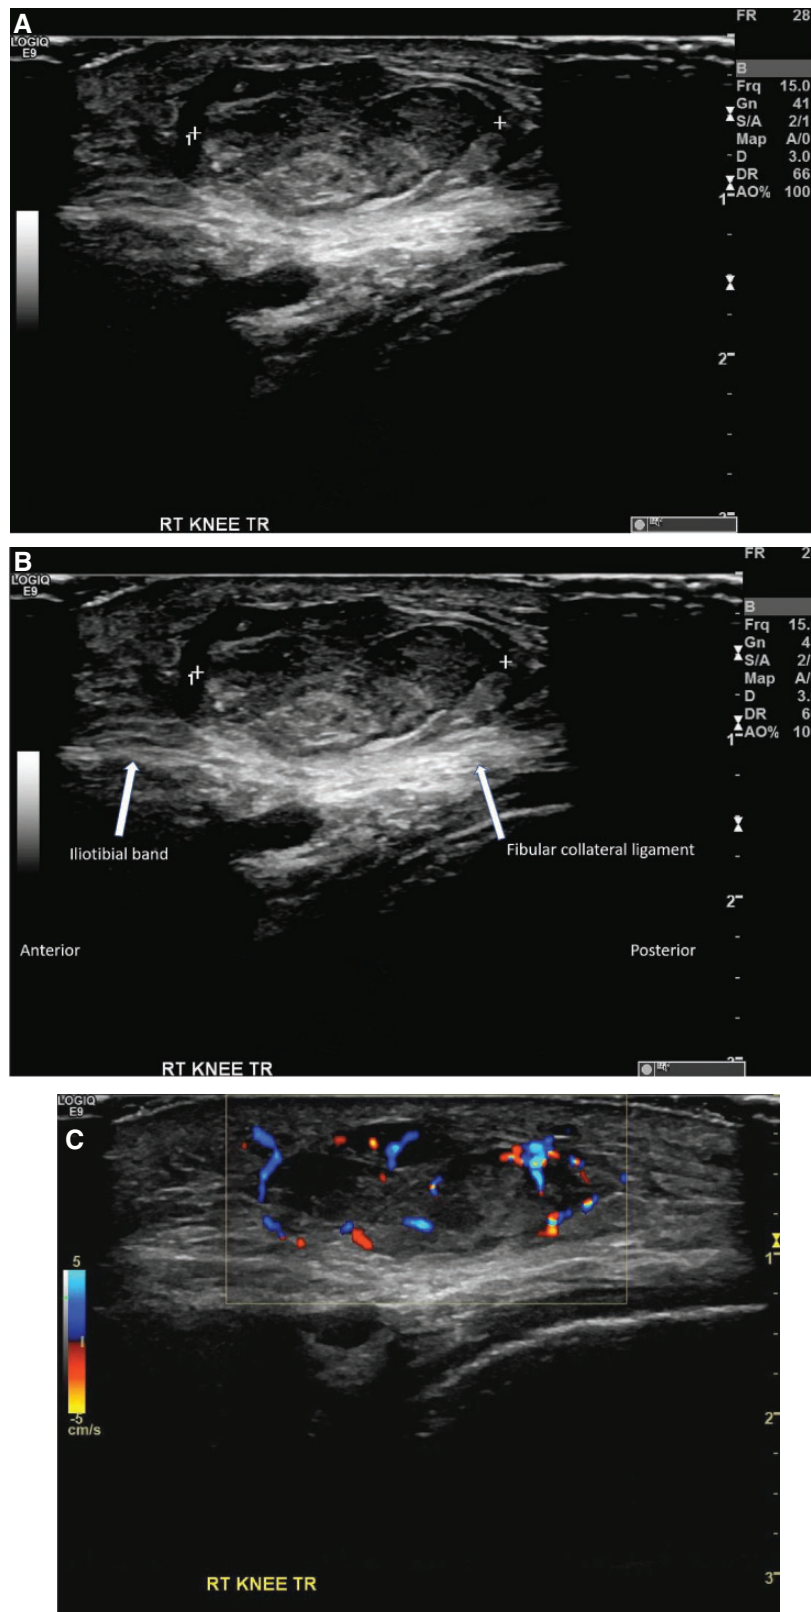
A transverse view of a heterogeneous mass with views including unlabeled (A) and labeled (B) and doppler (C). Important findings are both low and intermediate echogenic regions within the lesion. The lesion is superficial to the iliotibial band and fibular collateral ligament (B). Transverse image with doppler shows an important feature: prominent vascularity (C).
